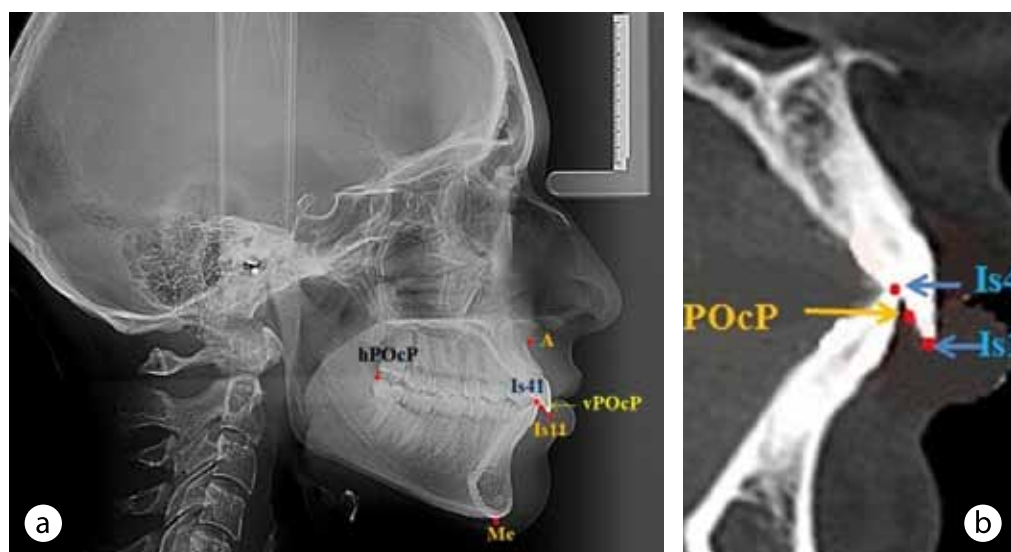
Anatomical landmarks on a telegentogram (a) and a cone-beam tomogram (b) for constructing an occlusal plane
